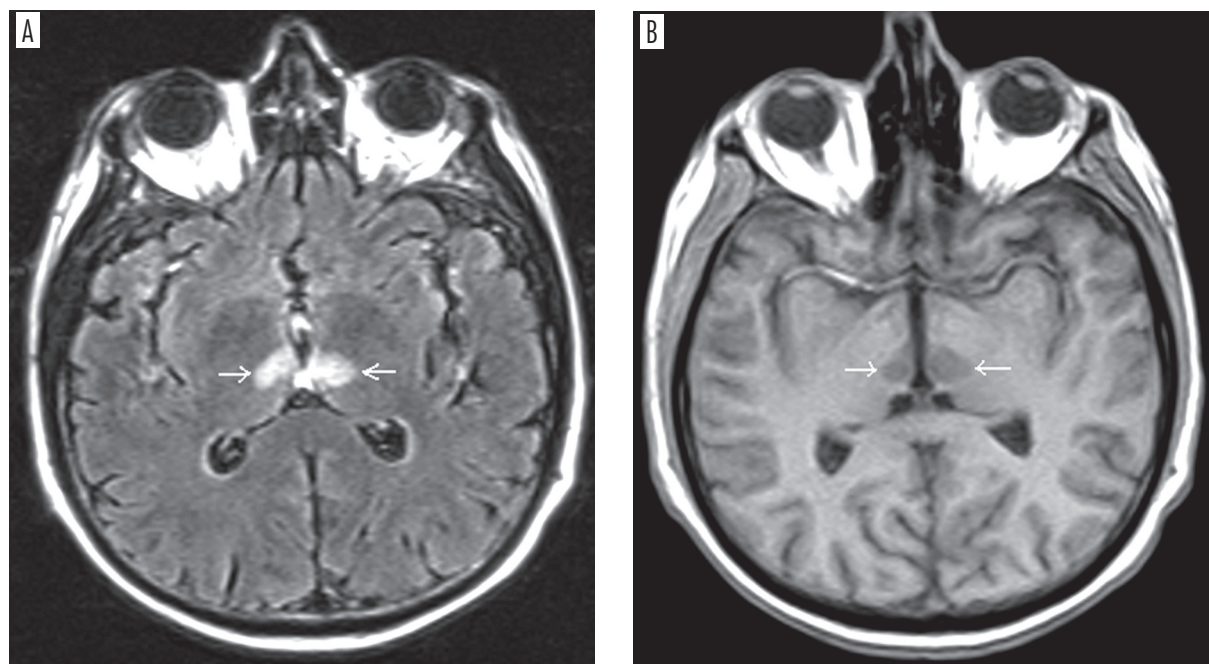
Magnetic resonance imaging of the patient with bilateral thalamic infarct. Axial FLAIR images (A) and T1-weighted images (B) are shown. Sites of lesion are indicated by arrows
